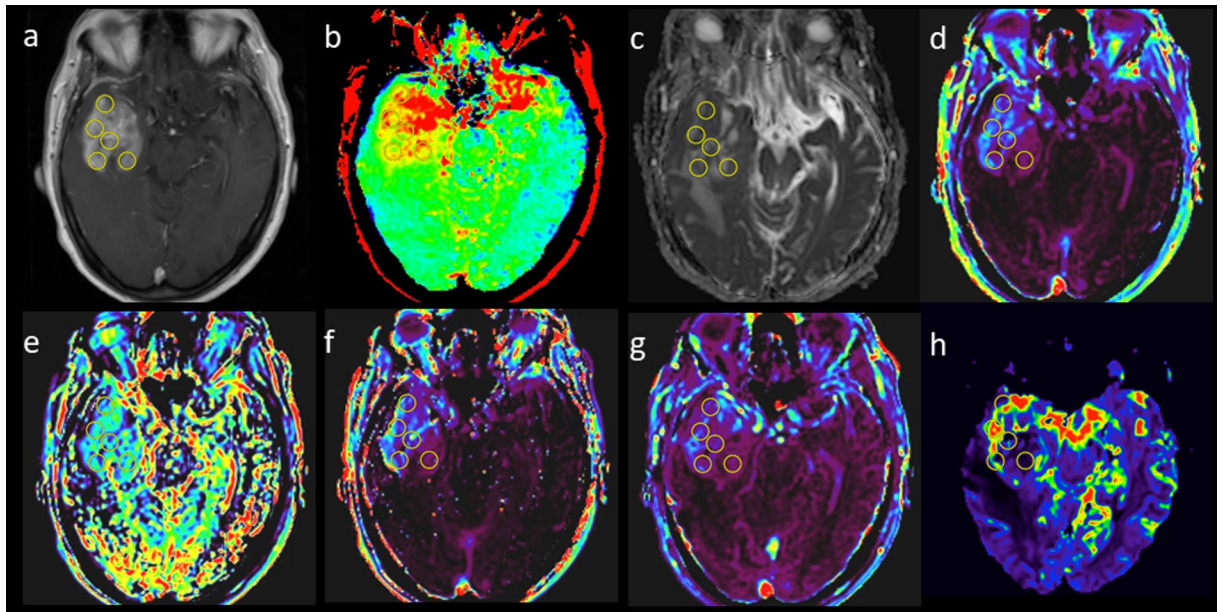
Region-of-interest (ROI) measurements in a 68-year-old female with glioblastoma. Round ROIs with a diameter of 10 mm are placed to fill the solid enhancing part of the tumor on contrast-enhanced T1-weighted image (a). The ROIs were copied onto maps of APTSI (b), ADC (c), K^{trans} (d), k_{ep} (e), v_e (f), v_p (g), and rCBV (h).
